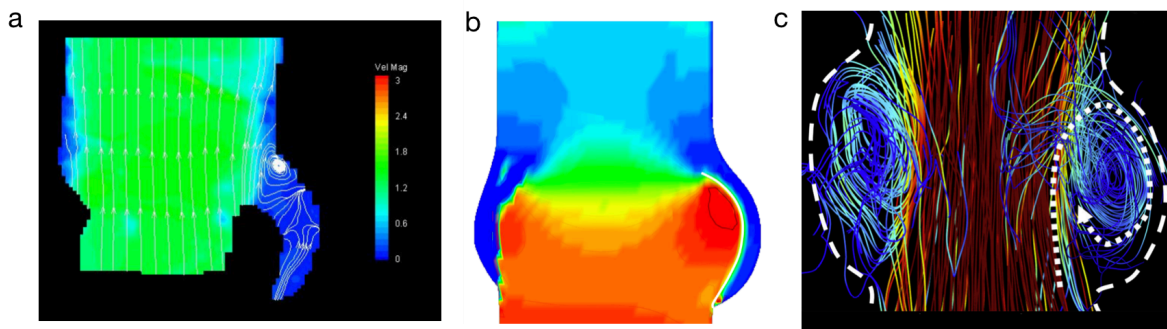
Cross-sectional images of native aortic district (a) PIV derived velocity field of a cross-section of the root at peak systole at an imposed cardiac output of 5 lpm at 100 mmHg mean aortic pressure. In comparison with (b) the computational cross-section<sup>250</sup>, and (c) 4D-flow MRI in vivo image, the in vitro leaflet does not extend as far into the sinus, is positioned too low, and does not reproduce the same vortical patterns.
